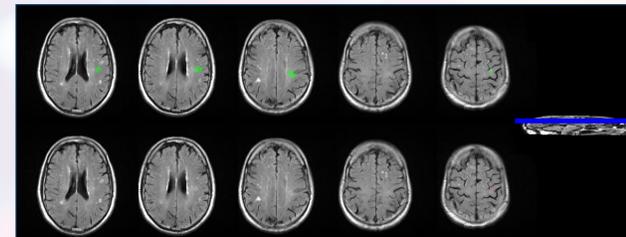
FLAIR MR scan of one of the 57 patients with CS included in the study. Each column represents the same slice level (same planar section within the brain) of the patient. The top row shows the lesion, outlined in green, that was identified by looking at the DWI and FLAIR MR images. The bottom row corresponds to the lesion (red) identified by looking at the FLAIR and T1W images.
